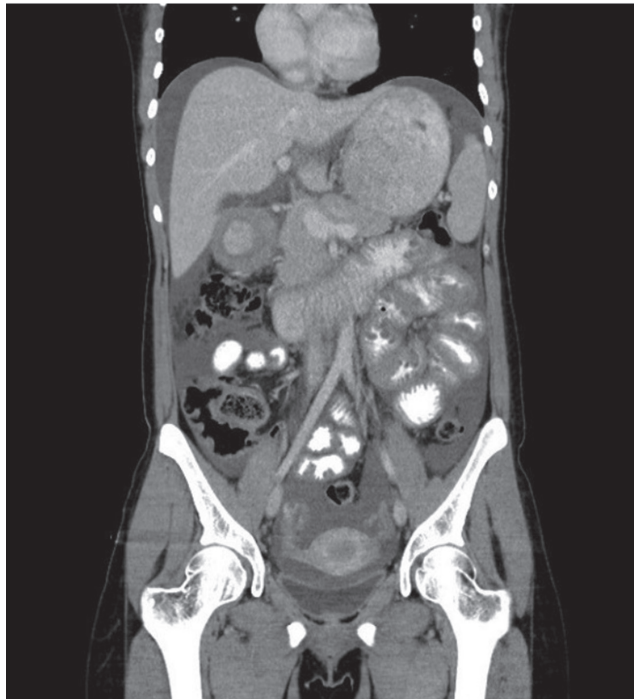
Abdominal computed tomography showed moderate ascites with thickening of the gastric antrum and small bowel walls
